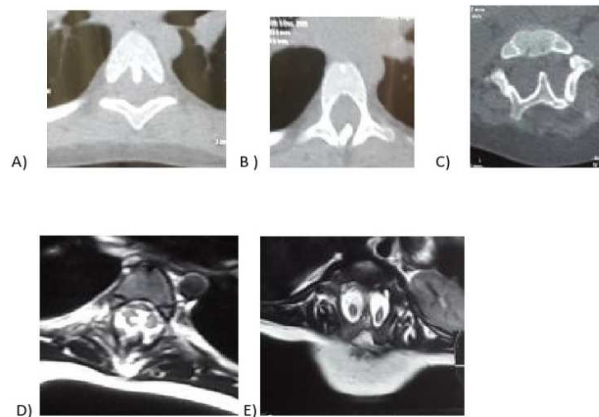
CT scan A, B – axial images at D6 level showing bony spur. C – axial images showing another located bony spur at L2 level. D, E – MRI T2 axial images at D6 (A) and L2 (E) level
